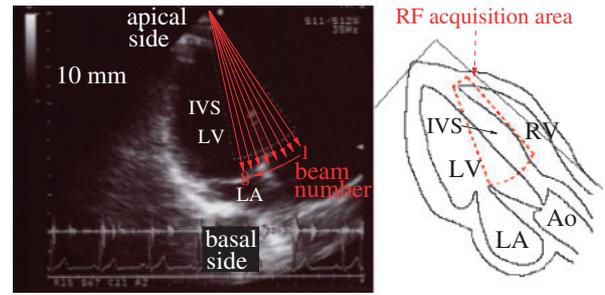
Cross-sectional image of the left ventricle in the apical approach obtained by conventional echocardiography for a healthy 24-year-old male. The arrows show the directions of the eight ultrasonic beams used for estimating the strain rate distribution in the IVS.
